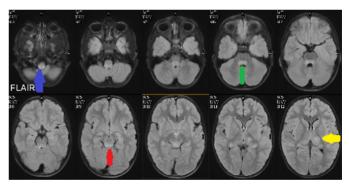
B: Rabies encephalitis- Axial FLAIR images showing hyperintense signal in posterior portion of midbrain (red arrow), pons (green arrow), medulla (blue arrow) & within left thalamus (yellow arrow)
